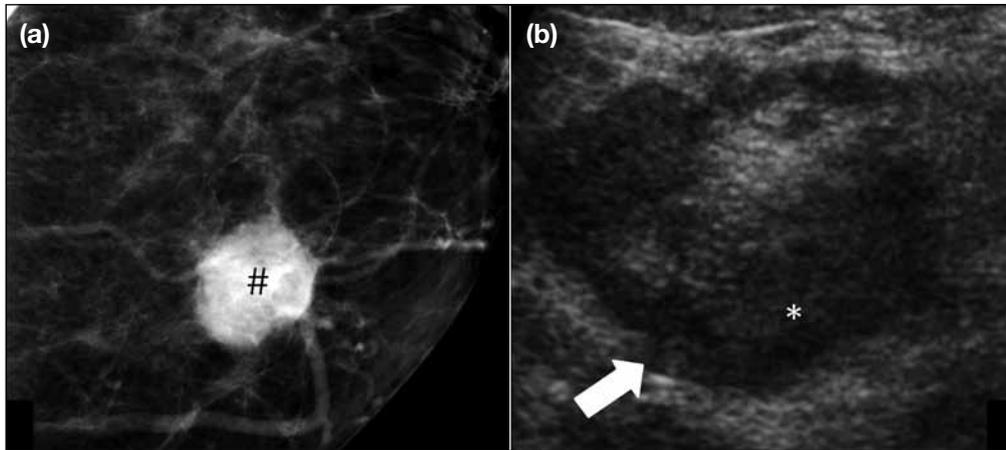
(a) Compression mammogram of the left breast of a 54-year-old woman showing an oval nodule as a hyperdense mass (#) with indistinct margins, located in the inferomedial quadrant. (b) Ultrasound image showing a hypoechoic oval mass (*) with indistinct margins (arrow) and longest axis parallel to the skin, located in the inferomedial quadrant.
